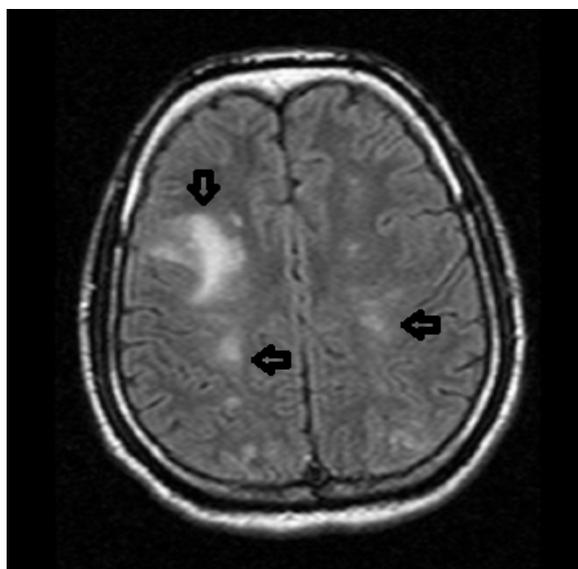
Brain MRI with gadolinium demonstrating multiple hyperintense lesions (arrows)
